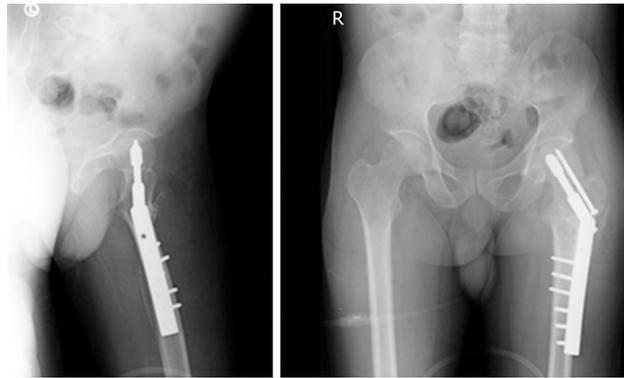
Postoperative AP and lateral radiographs of left proximal femur valgus Osteotomy demonstrating sliding hip screw fixation.
